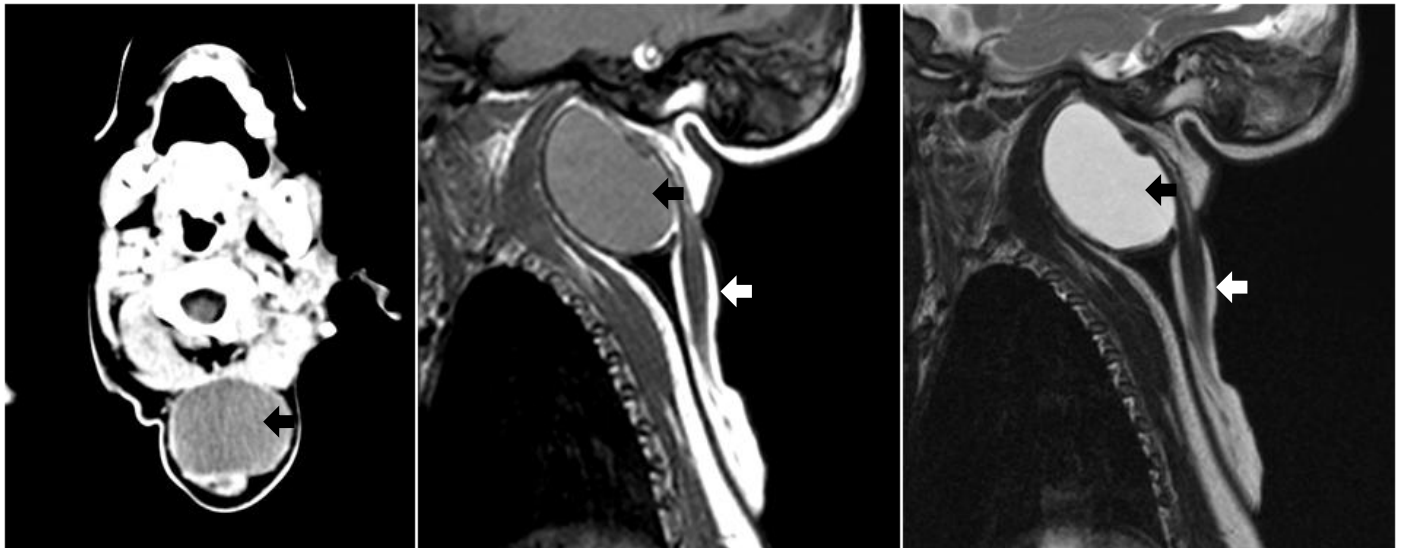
Axial contrast-enhanced CT (right), sagittal T1-weighted (middle) and sagittal T2-weighted images showing a soft tissue mass in the posterior cervical region (black arrow) and an accessory tubular structure arising from the autosite's occiput and coursing inferoposteriorly (white arrow).
